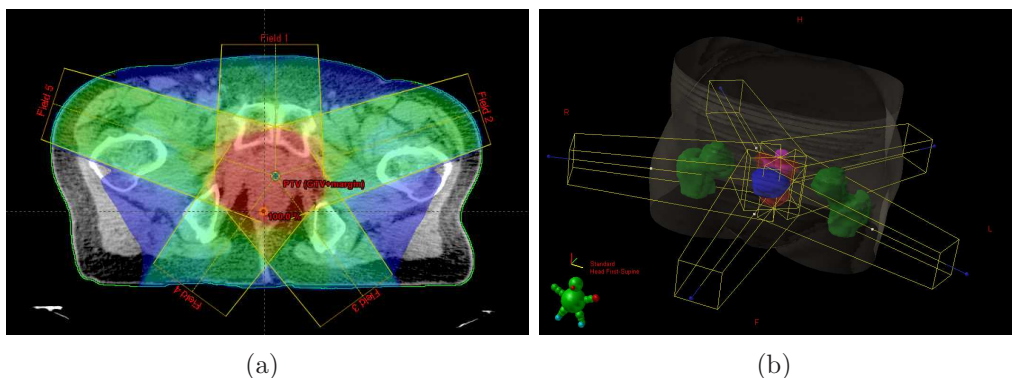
(a) A transversal plane of a five-field coplanar prostate plan generated in EclipseTM TPS. The calculated dose distribution is shown as a colormap superimposed on the CT image. The radiation beams intersect in the region of the tumor in order to spare the healthy tissue in the regions where the beam enters or exits patient. (b) A 3D view of the contoured organs and a field geometry in EclipseTM, (images used with permission, © Varian Medical Systems Inc., all rights reserved).
